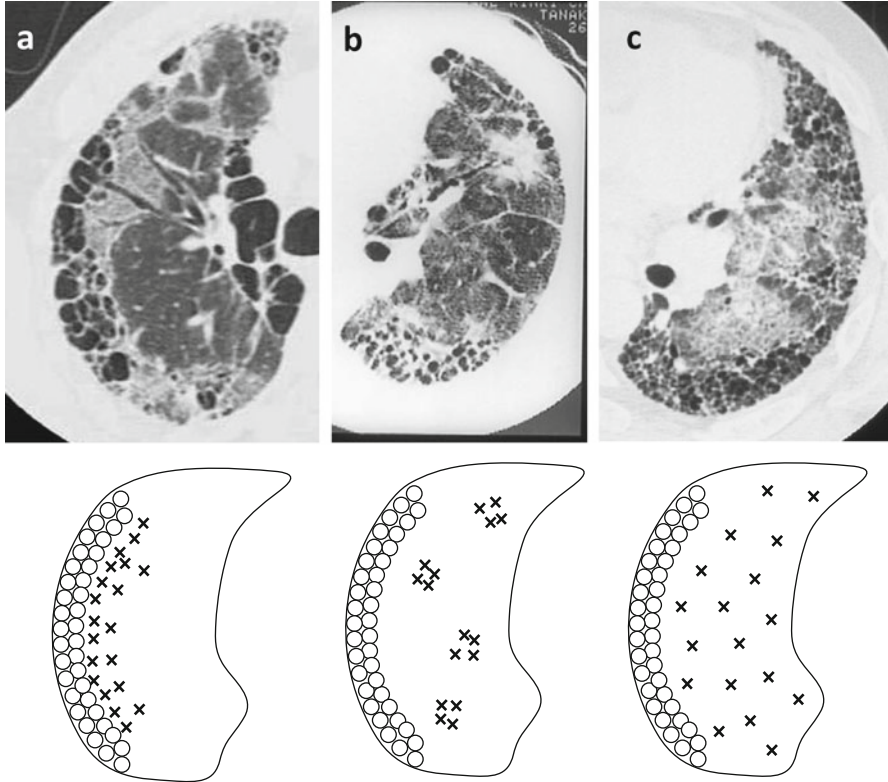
High-resolution computed tomography (HRCT) patterns of acute exacerbation of IPF: (a) peripheral pattern, (b) multifocal pattern, (c) diffuse pattern (Adapted from Ref. [44])
